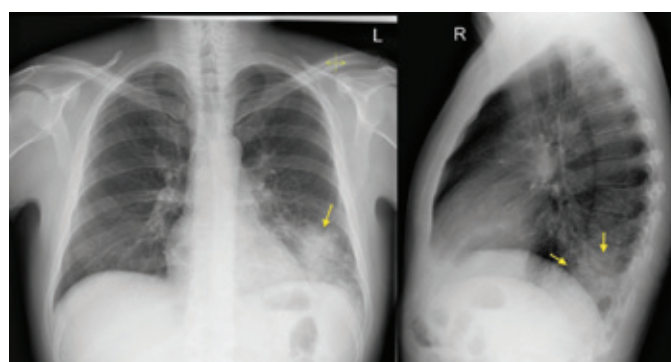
PA and lateral chest radiographs showing left lower lobe pneumonia (outlined by arrows).
